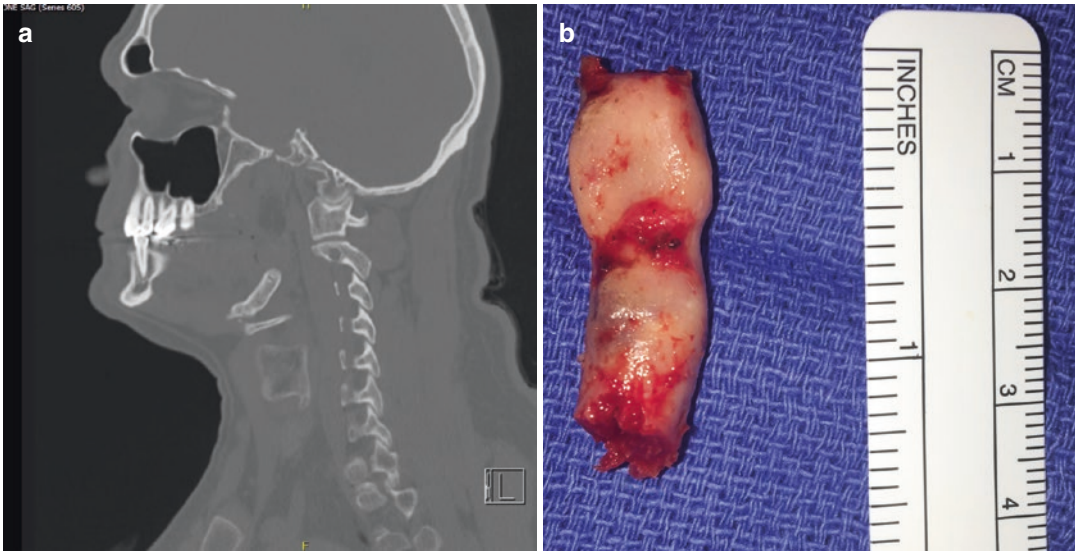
Non-contrast sagittal CT scan demonstrating a thick calcified stylohyoid ligament (a) which was removed at surgery (b) to relieve symptoms of Eagle's syndrome (images courtesy of M. Boyd Gillespie, M.D.)
